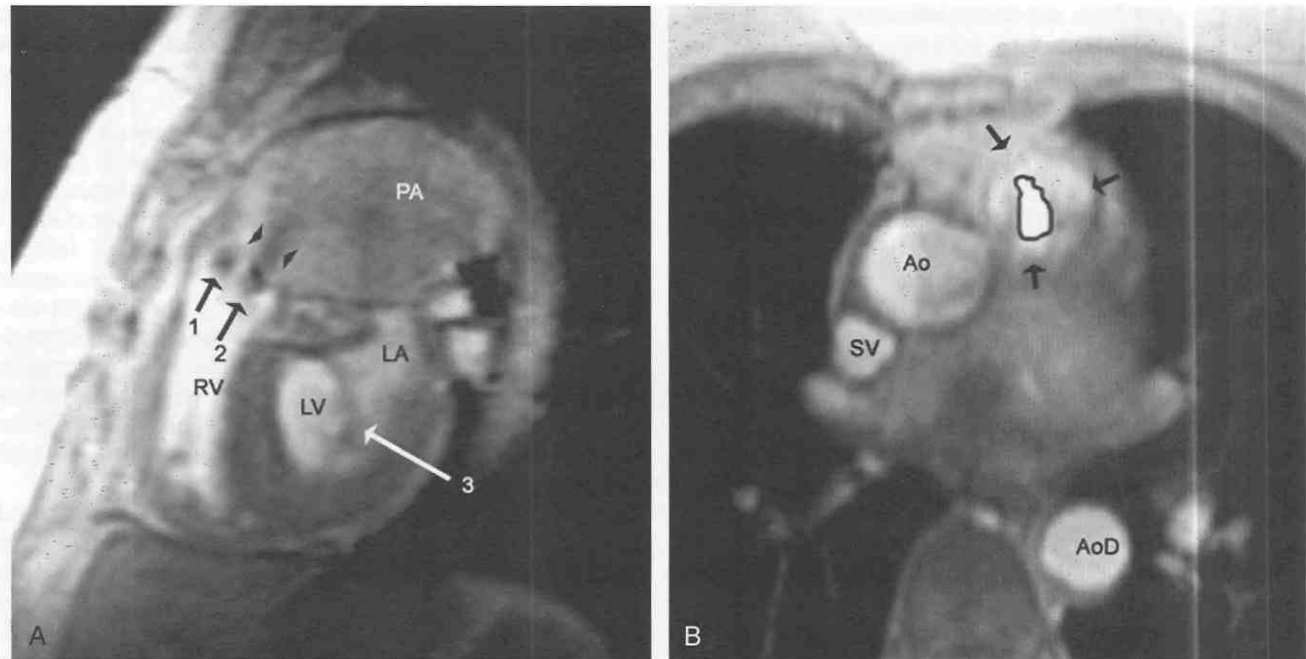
MR image obtained from a 74-year-old woman with congenital valvular pulmonic stenosis. *A*, Systolic sagittal gradient-echo acquisition obtained through the pulmonary valve. Two signal voids on the cusps of the pulmonary valve (arrows 1 and 2) represent calcific leaflet deposits. A fan-shaped jet of pulmonic stenosis (arrowheads) into the dilated main pulmonary artery (PA) can be seen. In this anatomic section, the anterior mitral leaflet (arrow 3) can be seen separating the left atrium (LA) from left ventricle (LV). RV, right ventricle. *B*, Systolic oblique axial section through the stenotic pulmonary valve (arrows). The valve orifice has been outlined in black. One can see how valve area can be directly quantitated by this technique. Ao, aorta; AoD, descending aorta; SV, superior vena cava.
